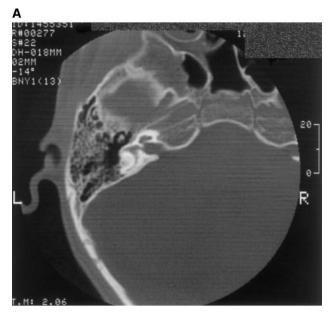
Computed tomography of temporal bone of IV-6 in axial (*a*) and sagittal (*b*) planes, showing no evidence of a dilated vestibular aqueduct.
